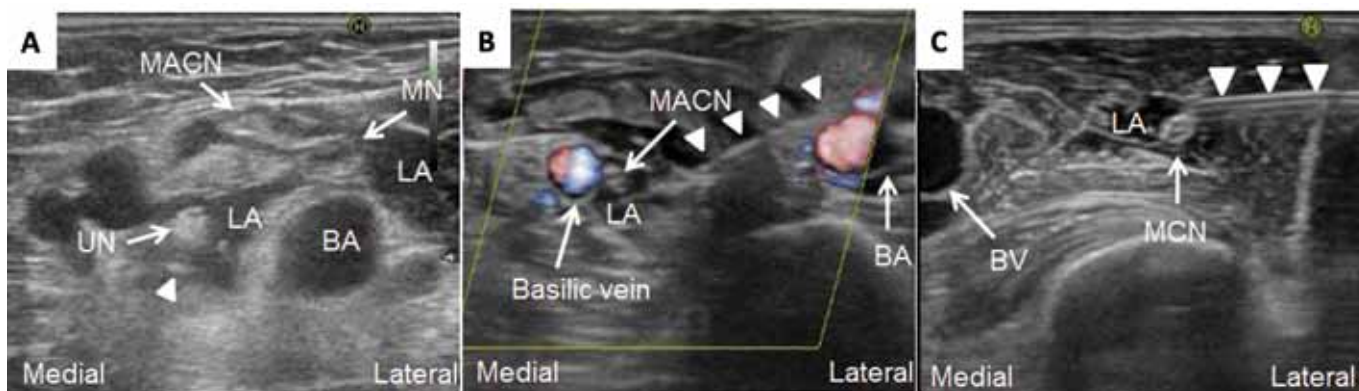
Real-time ultrasound-guided visualization of individual and selective nerves and injection of local anesthetic. Jiggling of the needle and hydrolocalization were helpful for definite visualization of the needle tip during the out-of-plane approach at the axilla (A). The tip of the needle was visible as a hyperechoic dot (A, arrowhead). The MACN along the basilic vein was blocked at the mid-upper arm and the MCN was blocked near the axilla (B and C). The interface of the needle shaft (B and C, arrowheads) and the nerves were visible along the long axis of the probe during the in-plane approach, and a donut sign (LA, B and C) was seen during infiltration of the local anesthetic. BA = brachial artery; BV = brachial vein; LA = local anesthetic; MN = median nerve; MACN = medial antebrachial cutaneous nerve; MCN = musculocutaneous nerve; UN = ulnar nerve.
